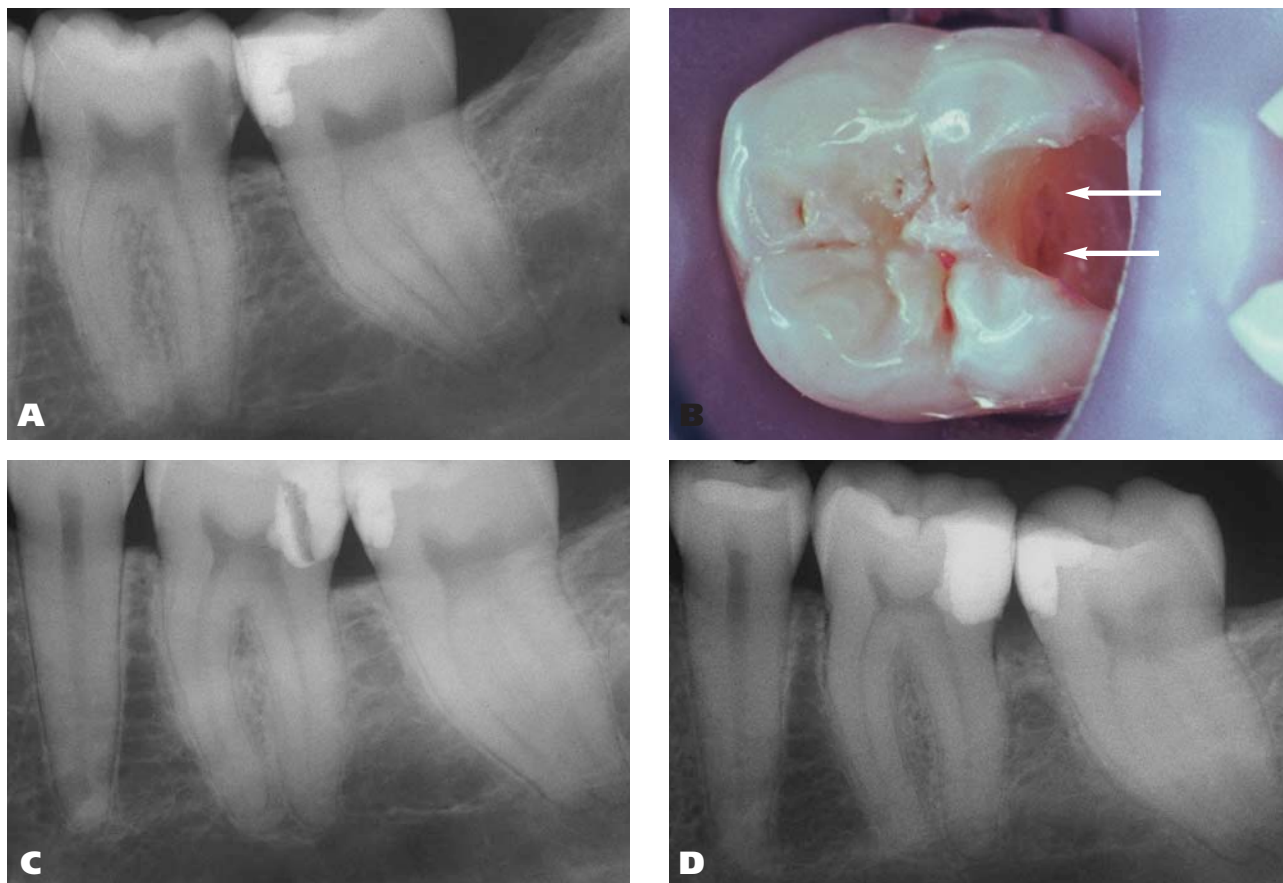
Treatment of molar with deep axial wall caries in 29-year-old female exhibiting a normal pulpal response to cold testing. A. Radiograph showing deep caries with no evidence of periradicular or furcation pathosis. B. Two exposures 1.0- to 1.5-millimeters to distal axial wall after excavation using caries detector and 5.25 percent sodium hypochlorite hemostasis (arrows). C. Posttreatment radiograph showing provisional restoration with mineral trioxide aggregate extending into the pulp chamber. D. Radiograph taken at the seven-year, 10-month recall appointment showing normal periodontal ligament and anatomical structures with no visual evidence of dentin bridge formation. The molar responded within normal limits to cold testing.
